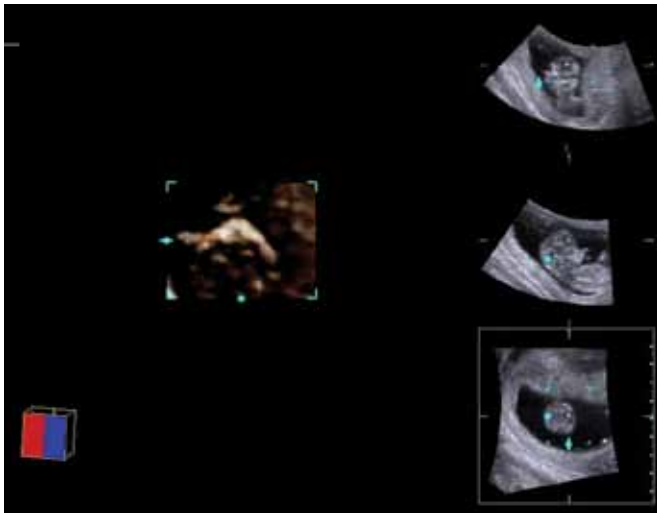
Multiplanary ultrasonography with an A quadrant, right part, middle with sagittal section of the fetal skull extremity, the quadrant B right part top with coronal section, quadrant C bottom right with axial section. To the left – the volume with “bottom view” of the jaw and primary palate with Skeletal Rendering software, the quadrilateral dotted with green represents this volume in the 3 quadrants A, B, C. Gestational age: 12 weeks.
